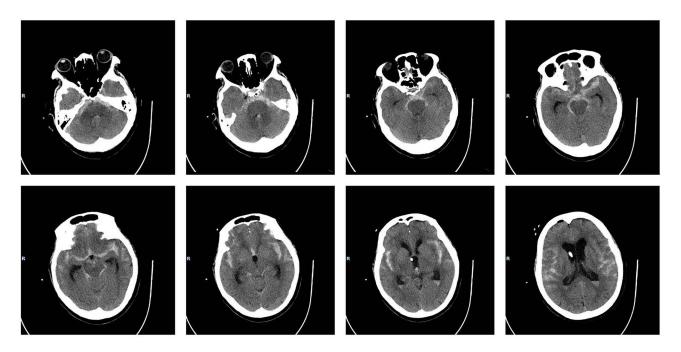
Imaging data of hydrocephalus. CT showed SAH around the midbrain, in the lateral fissure, hemorrhage ruptured into the ventricles, ventriculomegaly, and obstructive hydrocephalus formation.
